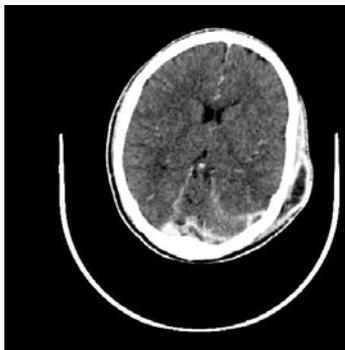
CT scan showing transverse sinus thrombosis and left-sided peri-auricular abscess collection.
